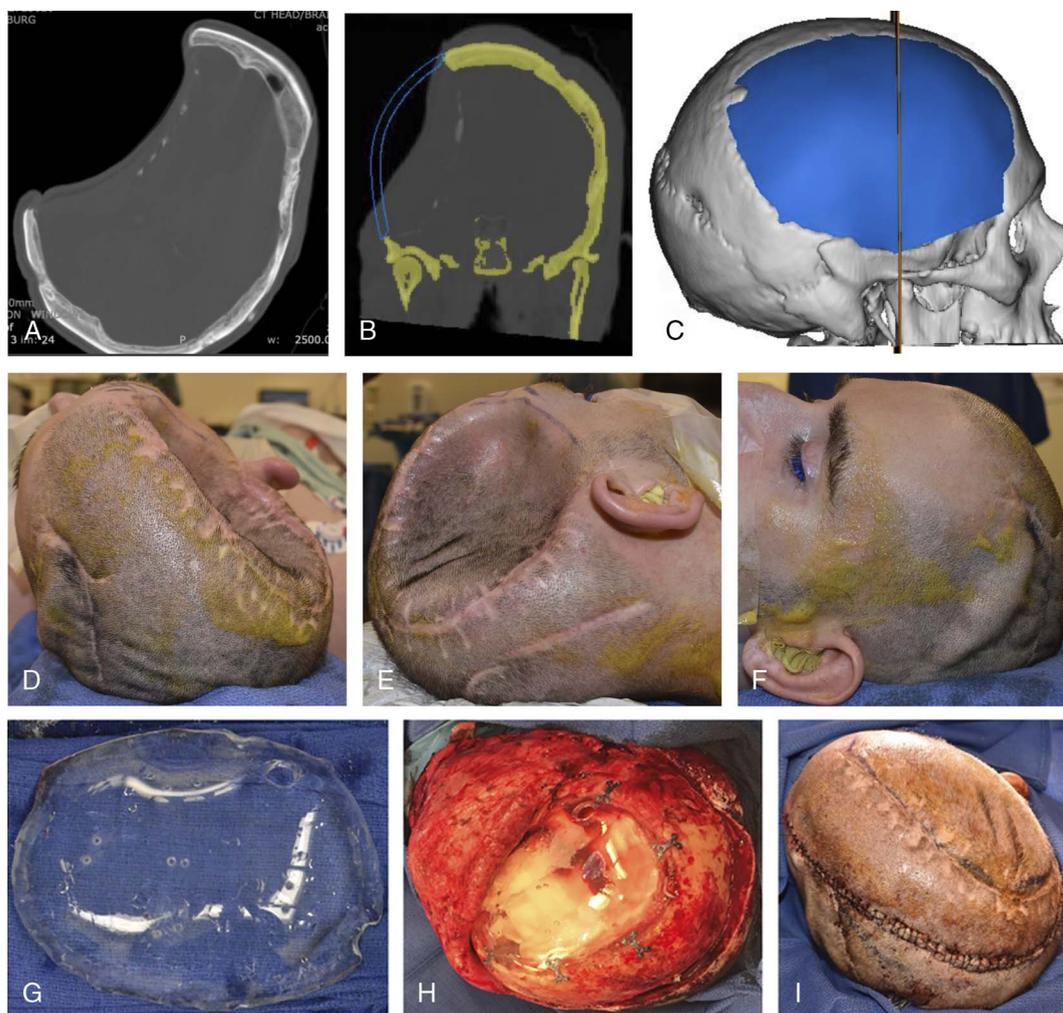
Two-stage cranioplasty for hemicranial defect status post traumatic brain injury. A, Horizontal CT scan image showing large right-sided hemicranial defect with severe encephalomalacia and sunken scalp flap. B, Virtual surgical planning image based on CT scan, coronal view. The bone is outlined in yellow, and the customized implant with precise fit is outlined in blue. C, Lateral view of 3D image used for 3D printing of the implant. The vertical line corresponds to the coronal cut-in (B). D–F, On table preoperative photographs showing large-sized, right-sided hemicranial defect with severe sunken scalp flap. There is extensive scarring from multiple prior surgeries, including (1) initial decompressive hemicraniectomy, (2) cranioplasty with replacement of autologous bone flap, and (3) removal of resorbed bone flap. Note also the prominent hydrocephalus shunt device, visible on the left side in images (D) and (F). G, Customized cranial implant on table. H, Intraoperative photograph showing pericranial-onlay flap dissection and implant secured in place with titanium plates and screws. Hemostatic gel foam is visible under the implant. I, On table postoperative photograph showing scalp sutured close. Note the location of the incision, since a new incision is created away from the edges of the bony defect, such that the incision is not directly overlying the implant.
